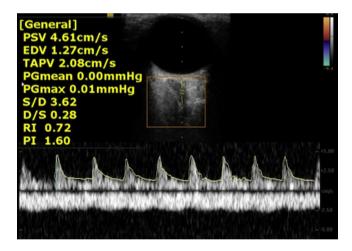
An example of color Doppler examination of the ophthalmic artery.
